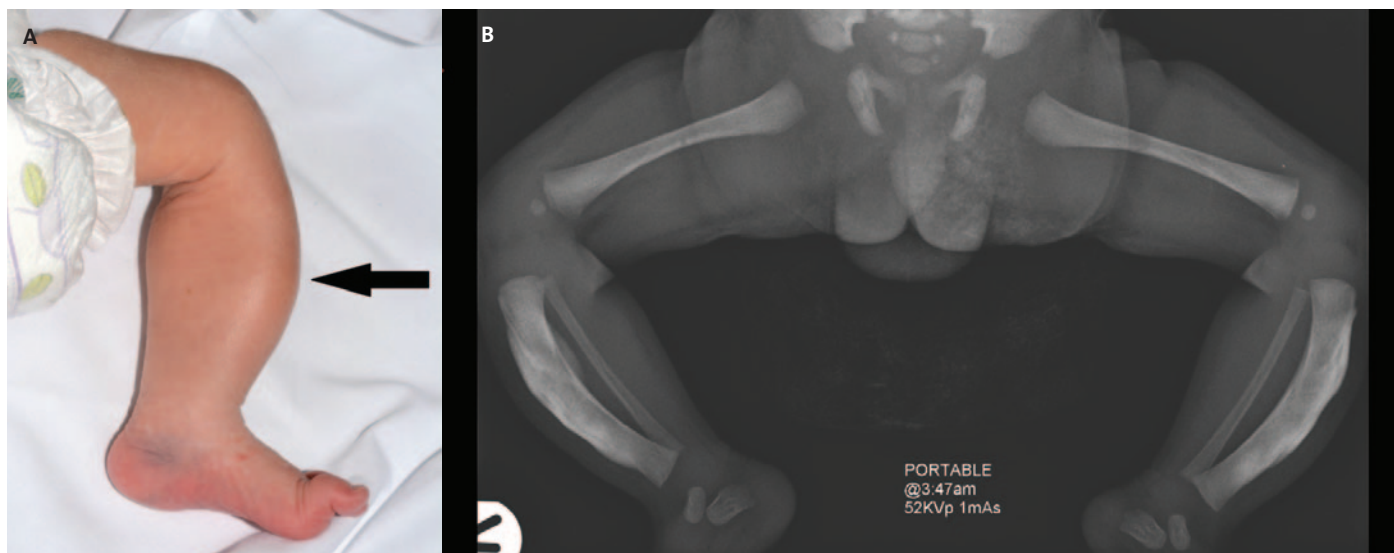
(A) The left leg demonstrating firm swelling on the tibial shaft. (B) A lower limb X-ray demonstrating bowing and hyperostosis with a thick irregular periosteal reaction along both right and left tibia.
